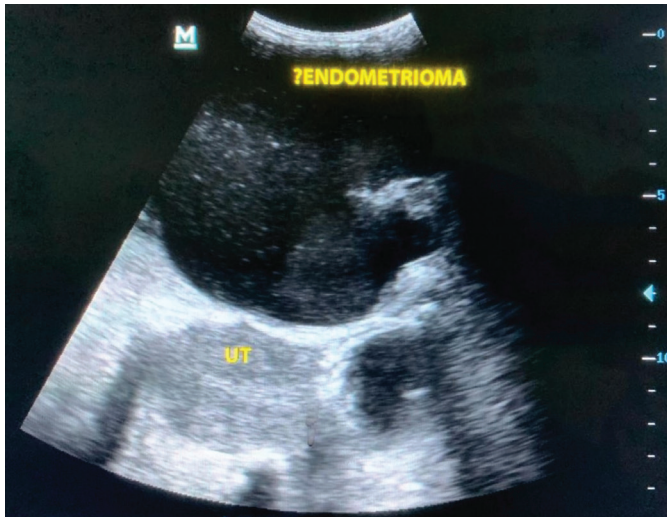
Ultrasonography showing hyperechoic large cystic mass with echogenic contents within with no vascularity
